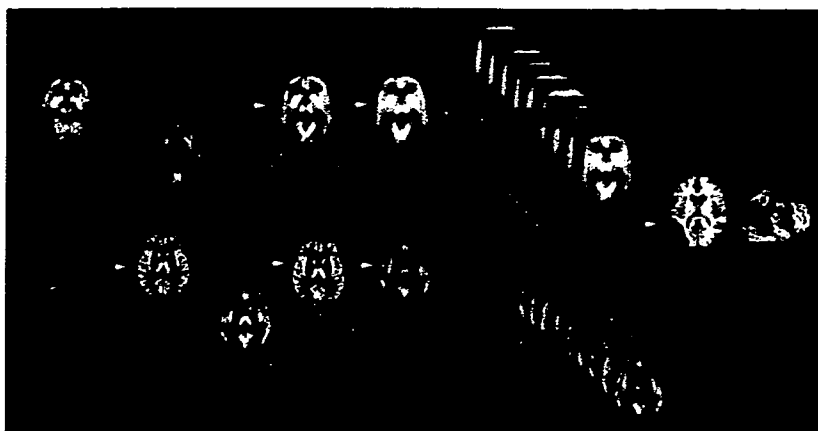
Procedures for statistical image analysis of brain perfusion SPECT and MRI data. Anatomically standardized and then smoothed SPECT or gray matter image of subject is compared with each normal database by z score analysis. Obtained z score maps are displayed by overlay on anatomically standardized MRI template.
